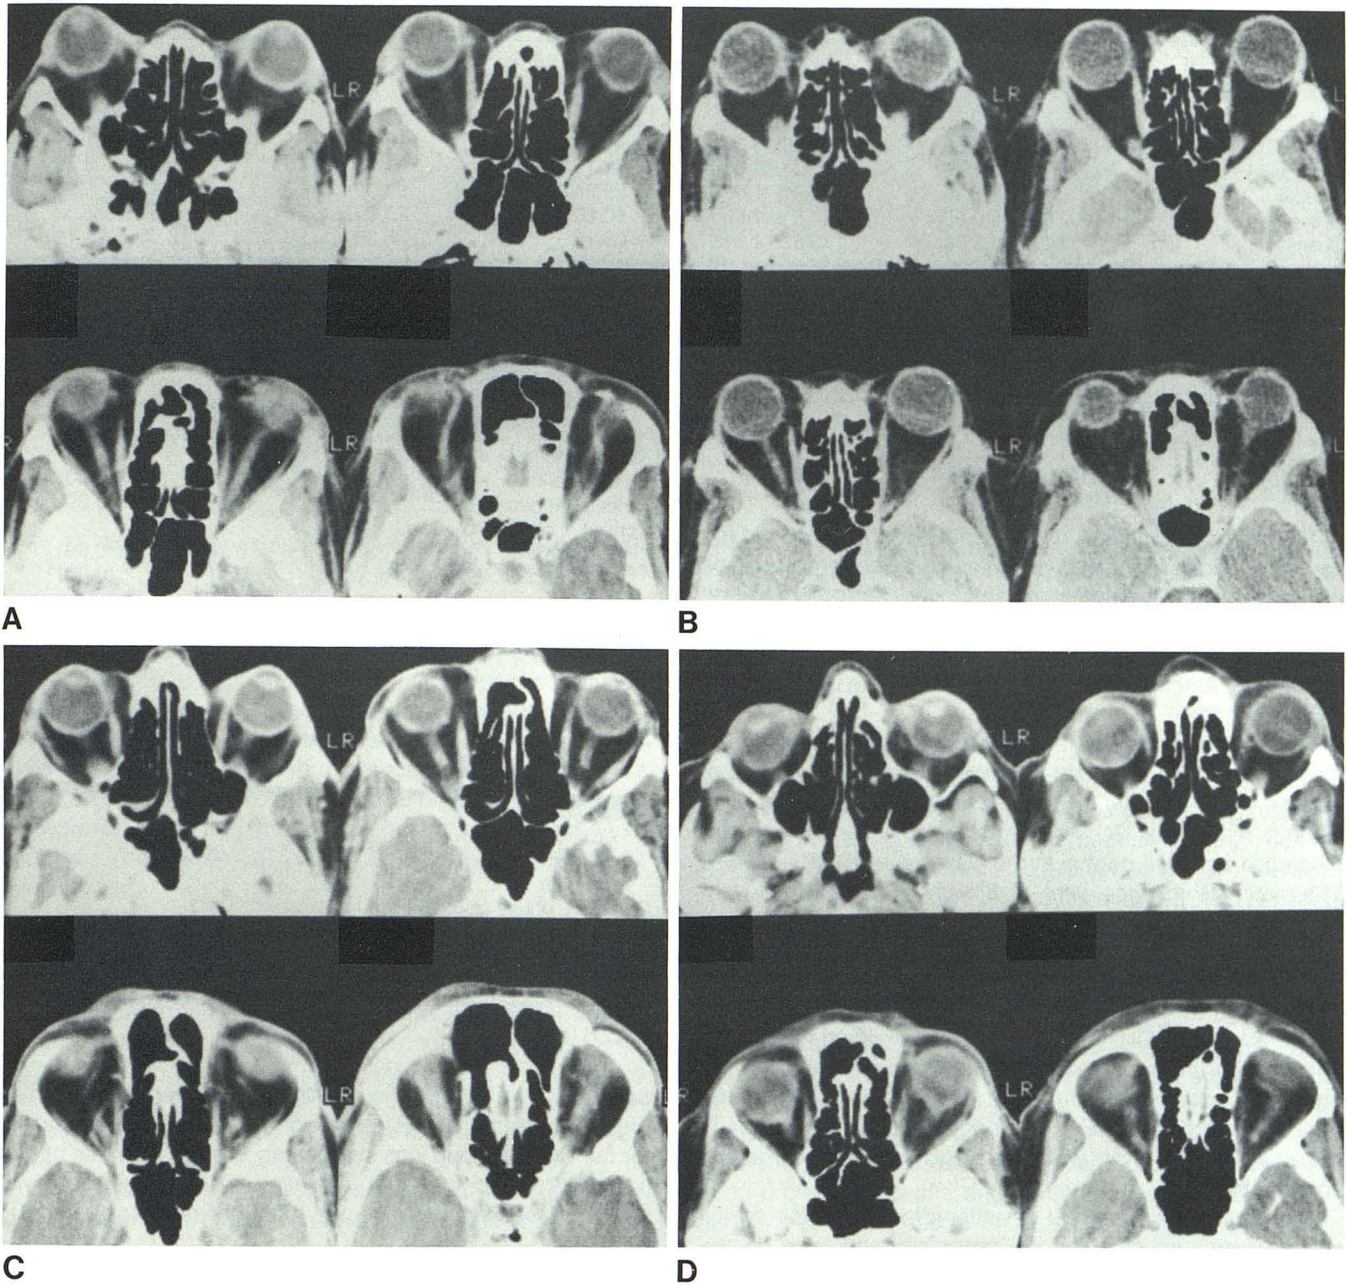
CT appearance of excess fat exophthalmos. A, Axial orbital CT sections in obese patient. Bilateral proptosis, normal extraocular muscles, and no evidence of discrete orbital mass. Orbital septa bowed anteriorly. Apparent bilateral increase in orbital fat. B, Orbital scans in patient with Cushing syndrome
